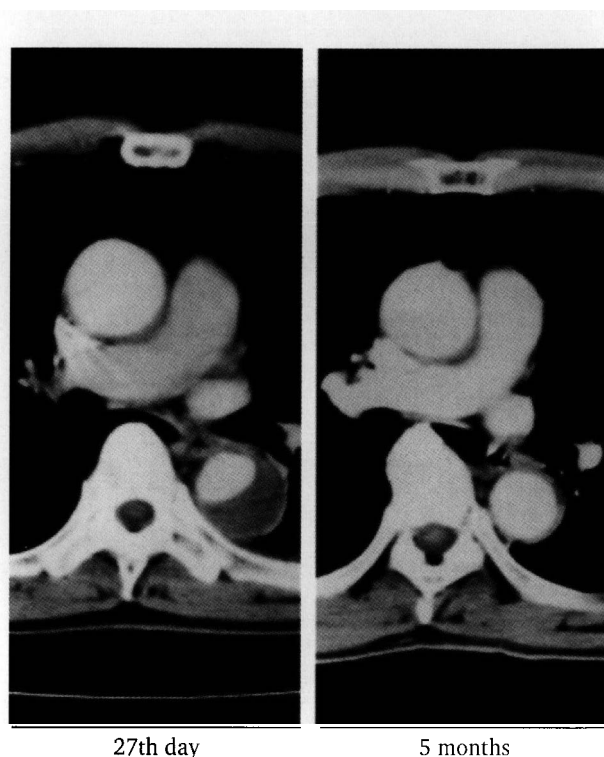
Follow-up computed tomography (CT). Left, CT obtained on the 27th day of illness showing narrowing of the true lumen and thickening of the wall accompanied by thrombotic occlusion in the descending aorta. Dilatation of the ascending aorta and enhancement of the dissecting lumen are not evident. Right, CT obtained 5 months after onset showing resolution of the narrowing of the true lumen and thrombotic occlusion.
